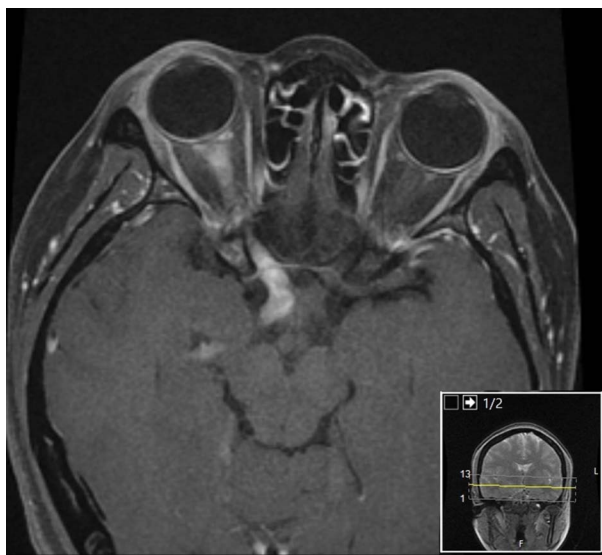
Axial image from a contrast T2 head MRI demonstrating long unilateral tract inflammation.
